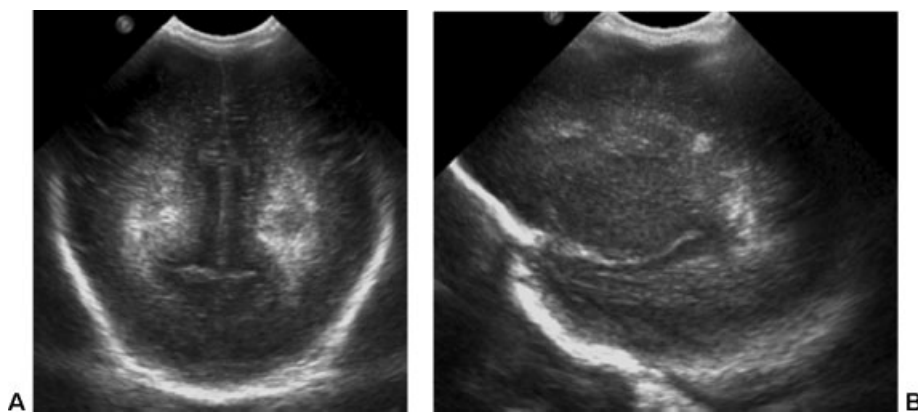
(A) Coronal and (B) sagittal cranial ultrasound at 7 days of life showing periventricular echodensities.
